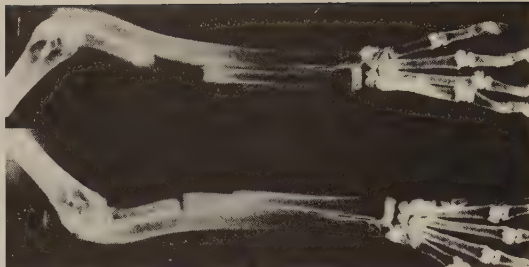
Roentgenograms 3 weeks after reoperation.
